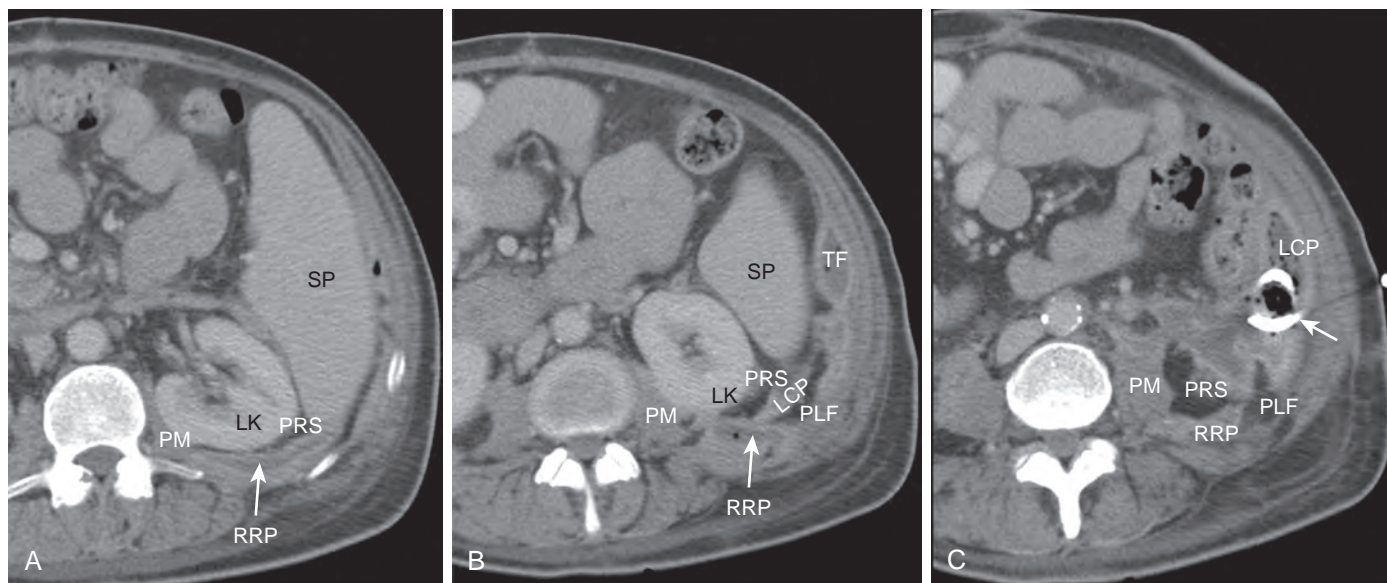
Collection in the retrorenal plane extending from the pelvis to the diaphragm. A. CT section at the level of the inferior left hemidiaphragm shows a collection in the retrorenal plane (RRP) extending lateral to the psoas muscle (PM) behind the fat in the perirenal space (PRS) and left kidney (LK), to the left of the spleen (SP). B. A CT section inferior to that in A shows the collection in the retrorenal plane (RRP), which has expanded into the posterolateral fat pad (PLF). There is extension of the collection into the superior extent of the lateroconal plane (LCP). Also note the collection along the transversalis fascia (TF). C. Inferior to section B, collections in the lateroconal plane and along the transversalis fascia have merged into one collection containing a drainage catheter (arrow).
